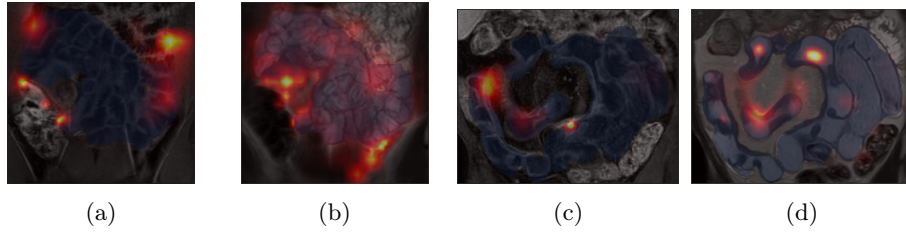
Feature attribution maps for stenosis prediction. The ileum segmentation is overlaid in blue, while red–yellow regions indicate areas with high feature attribution. (a,b) T1-weighted and T2-weighted MR images from a patient without stenosis. (c,d) T1-weighted and T2-weighted MR images from a patient with stenosis.
